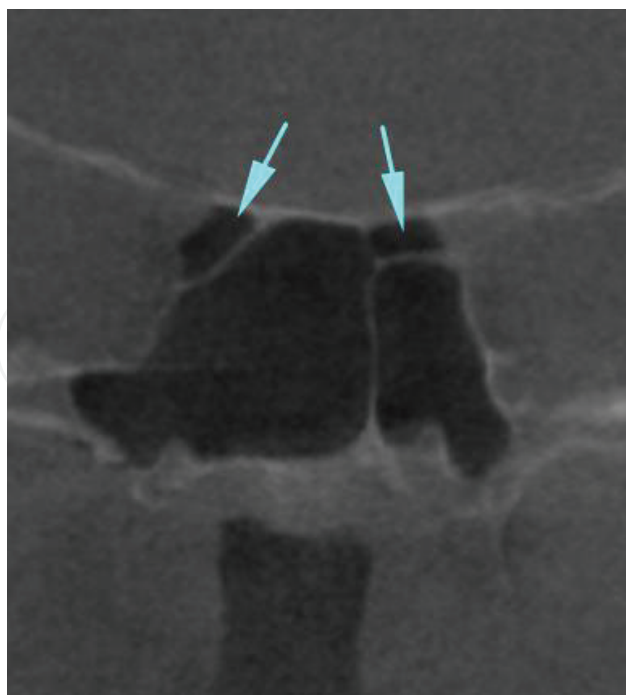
Coronal CBCT images. Bilateral onodi cell and its close relation with the optic nerve.
